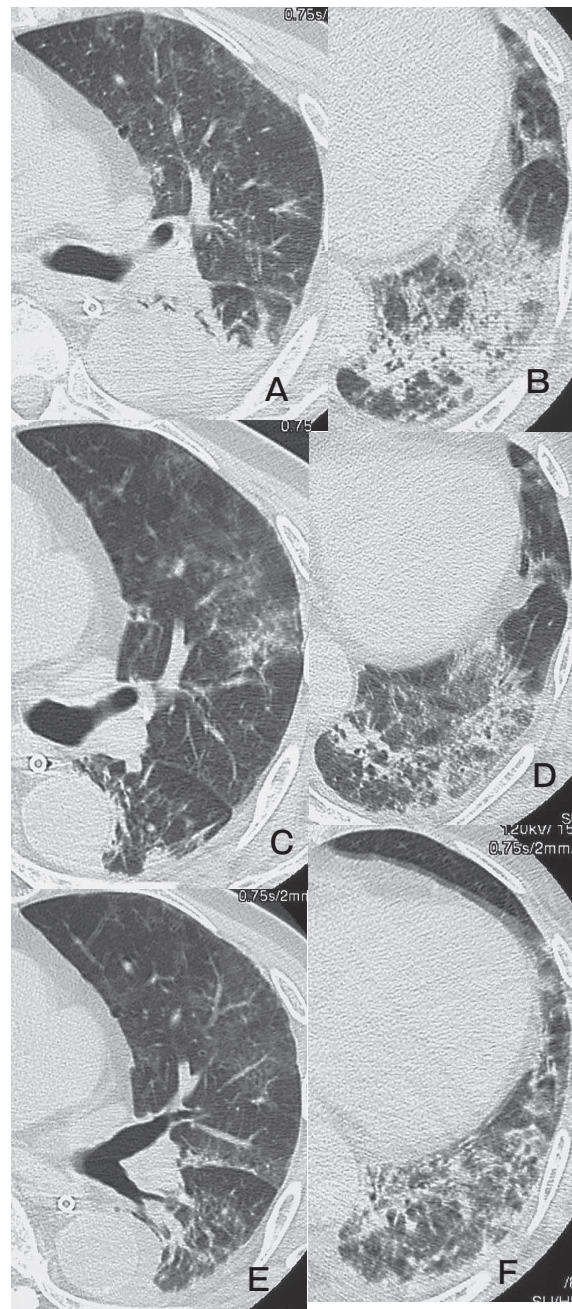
Panels A and B show the HRCT findings in case 7 on the day of TMP/SMX introduction, panels C and D show the HRCT findings at 14 days after TMP/SMX introduction, and panels E and F show the findings at 40 days. Panels A and B show abnormal shadows of the underlying acute lung injury. Panels C and D show the emergence of irregular infiltration in the left upper lobe, and the improvement of consolidation in the left lower lobe. In panels E and F, the previously emerged infiltration in the left upper lobe has almost disappeared, while the diffuse infiltration in the left lower lobe and ground glass opacity seen in the dorsal part of the left upper lobe have worsened.
